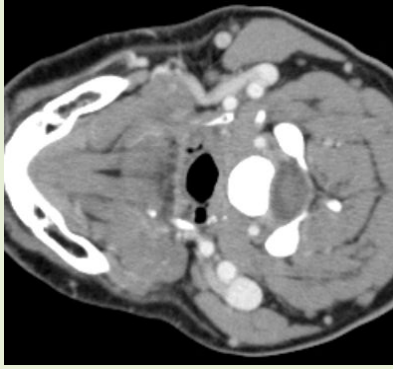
Computed tomography (CT) scan of the neck with contrast (axial view) showing submandibular gland asymmetry, right > left.
